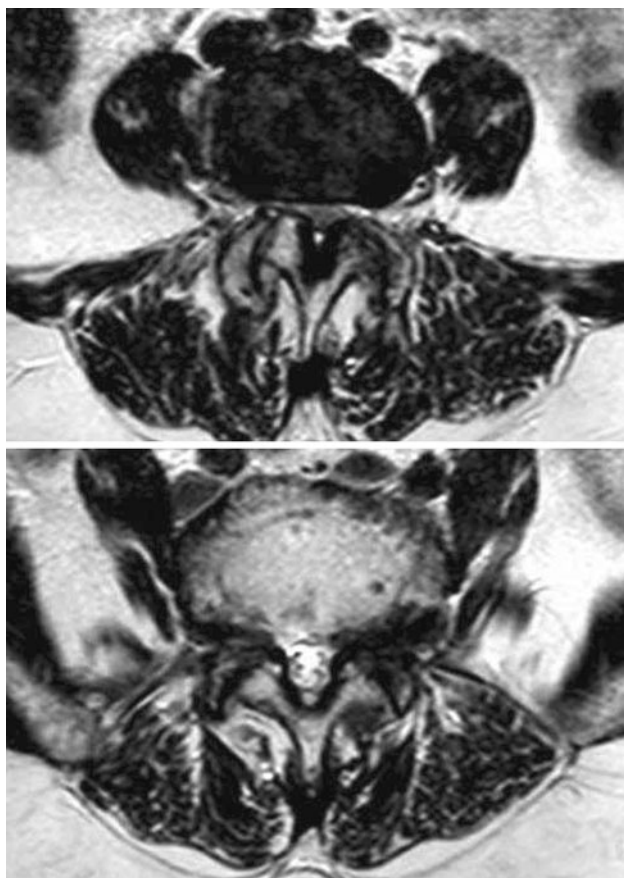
Axial T2-weighted MR scans of both presacral intervertebral segments demonstrating the degree of central and foraminal stenosis
